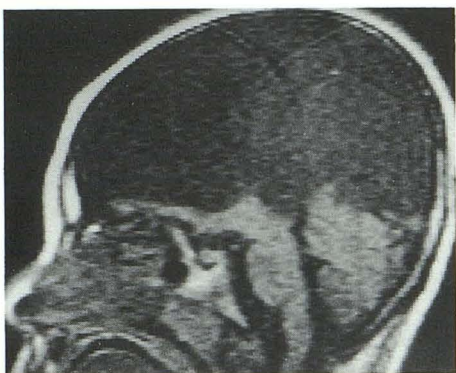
Hydranencephaly in patient born at term (case 38). Sagittal T1-weighted image (600/30/1) reveals minimal subfrontal brain and otherwise absent supratentorial brain. Posterior fossa is normal.
